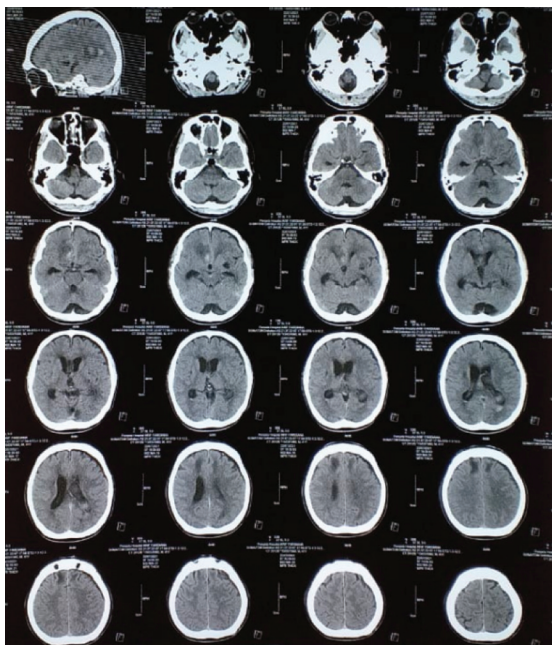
Evaluation of CT scan on postoperative EVD day 15.
